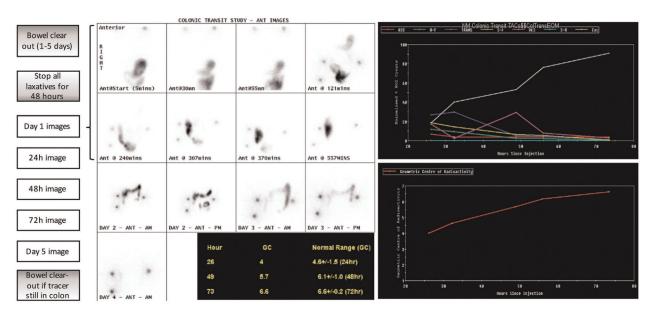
The investigation protocol and an example of normal colonic scintigraphy images (courtesy of Dr Lorenzo Biassoni, Consultant in Nuclear Medicine, Nuclear Medicine Unit, Radiology Department, Great Ormond Street Hospital).
